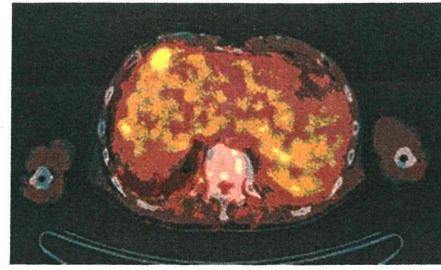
FDG PET/CT scan shows an 18x12-mm nodule located between the diaphragm and liver. It displayed strong FDG tracer uptake.
